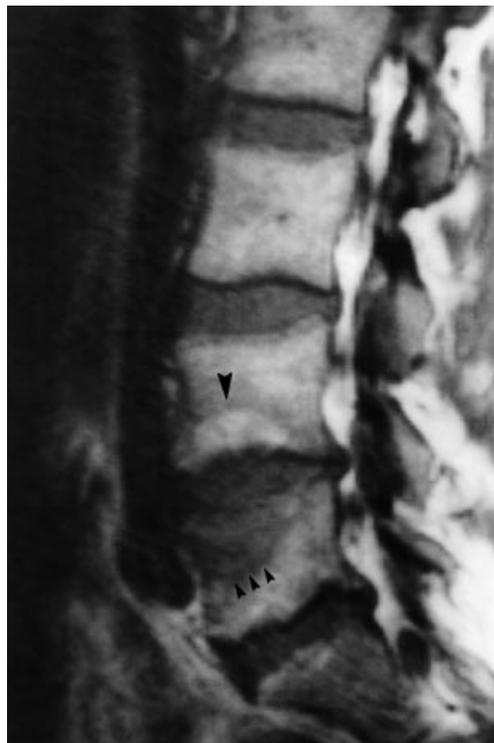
T1-weighted sagittal (TR 500 ms, TE 15 ms) precontrast image reveals high signal intensity antero-inferior part of the vertebral body L4, findings consistent with fat accumulation (big arrow head) and low signal intensity antero-superior part of the vertebral body L5 indicating bone marrow oedema (small arrow heads). Note also that the erosion of the vertebral body L4 is sharply corticated while the erosion at the level of L5 shows indistinct contour.
